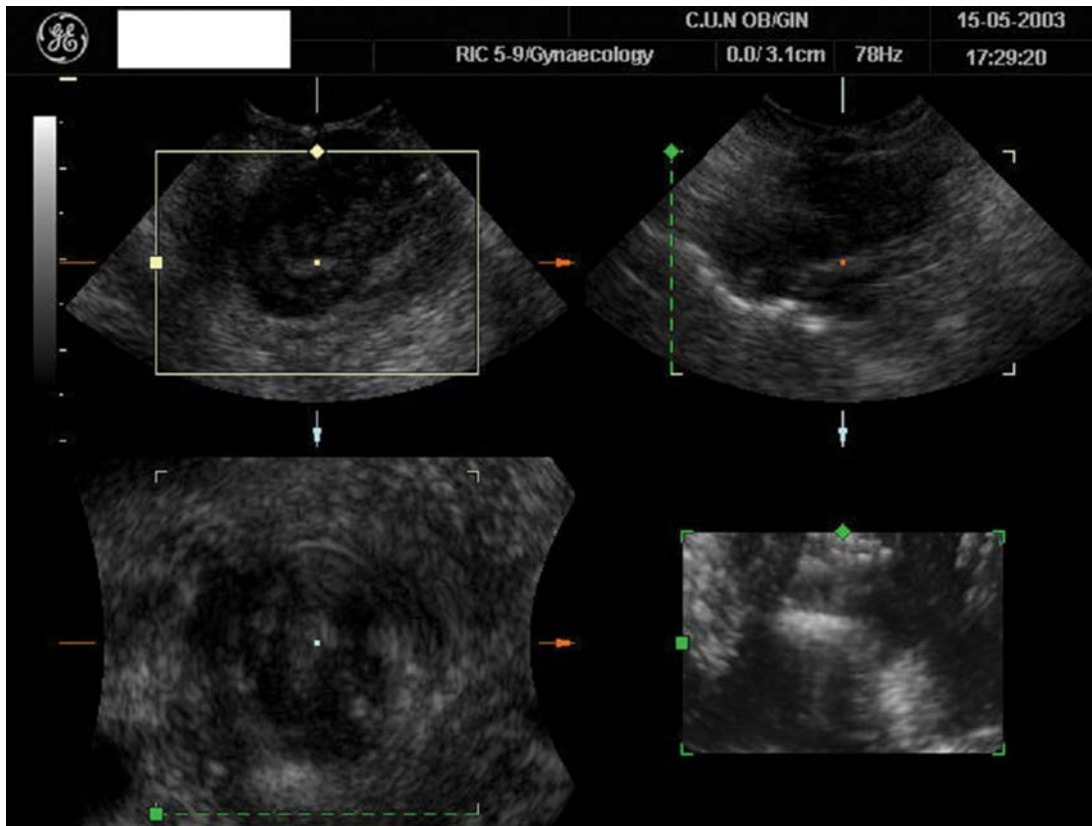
Three-dimensional ultrasound from a vaginal carcinoma. In this case, the lesion is hypoechoic with irregular contour.
